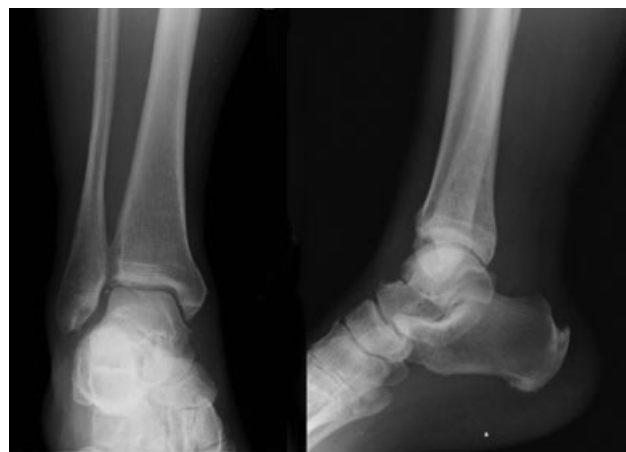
Initial standard right ankle radiograph.
